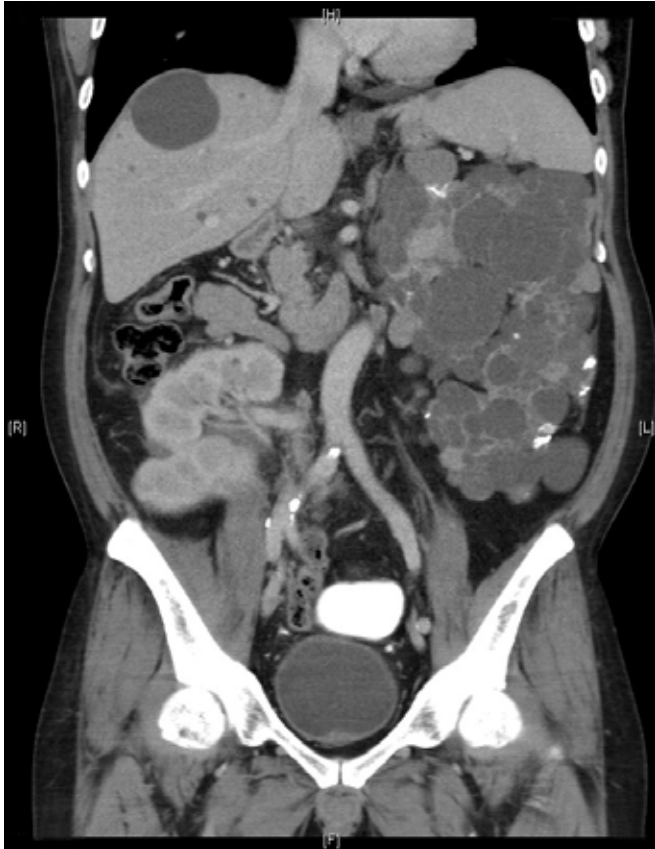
CT image shows a well-perfused right upper transplant kidney with its hilum.
